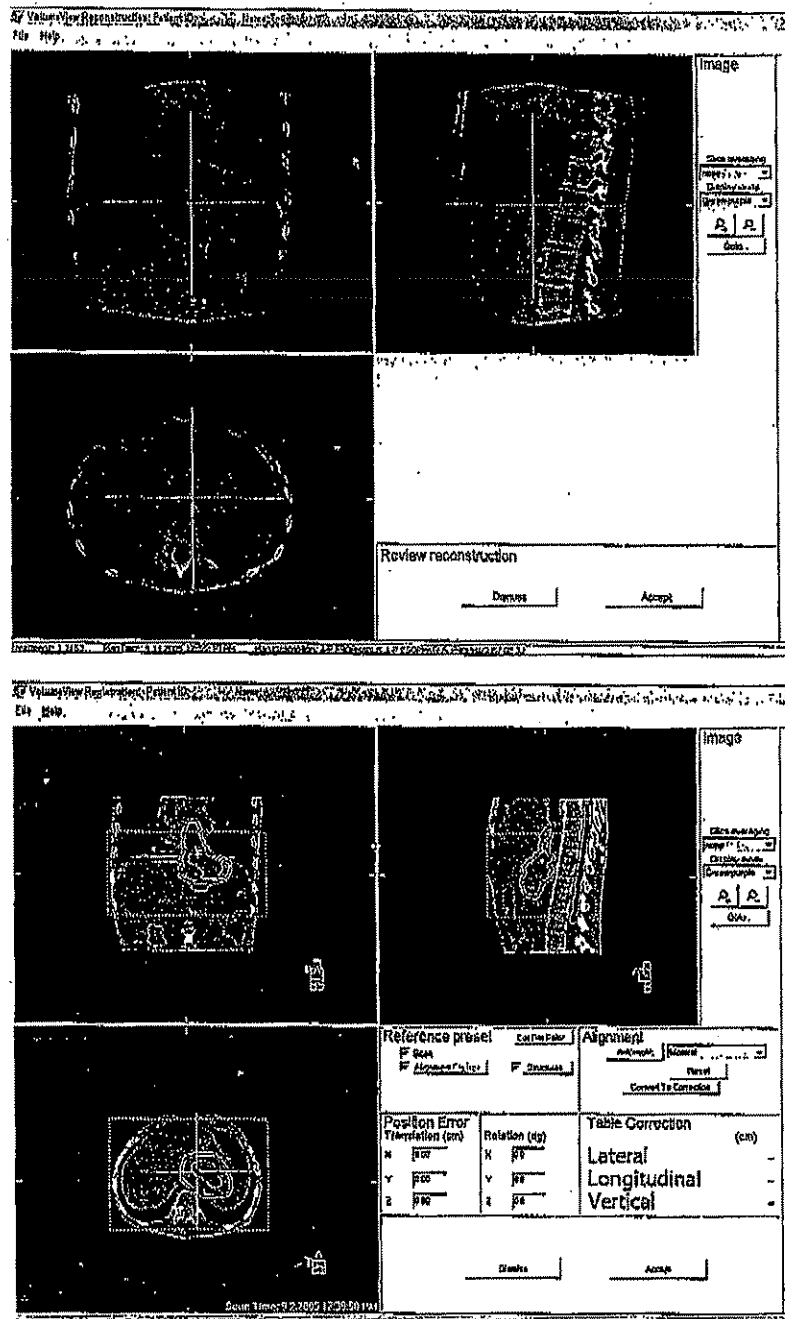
Elekta Synergy XVI display screens showing the image registration process. The difference between the prescription and CBCT data sets is calculated and displayed as translation along and rotation about the three axes; subsequent treatment table adjustments are made and then the patient is treated.
